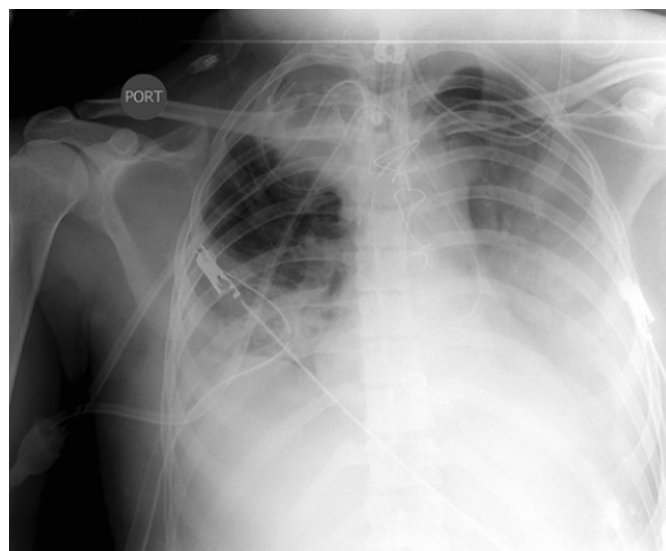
Chest X-Rays before beginning extracorporeal therapy (for Abstract 22).
